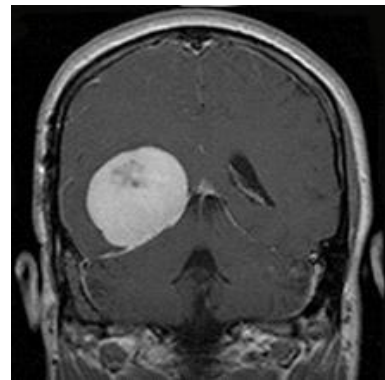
MRI of meningioma of tentorium cerebelli.
